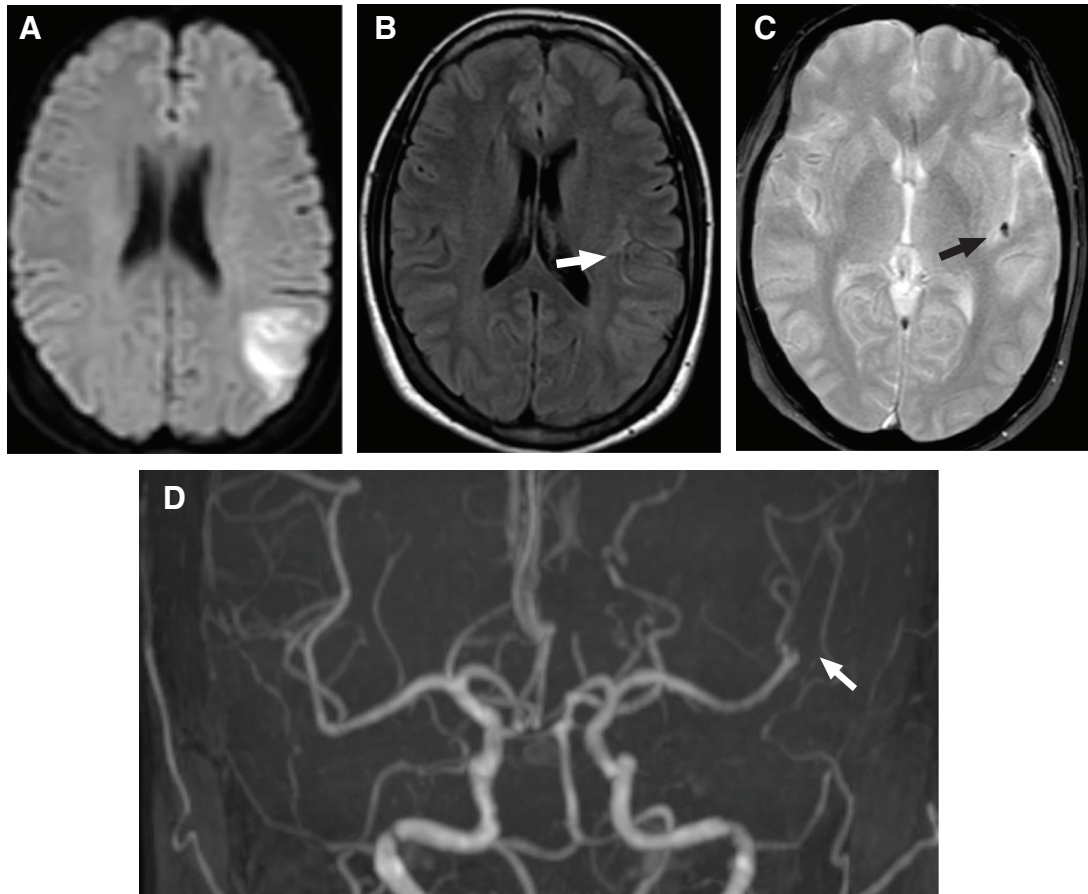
(A) Diffusion-weighted imaging revealed a high intensity area of the left parietal lobe. (B) Hyperintensity vessel sign was positive on FLAIR (white arrow). (C) Susceptibility vessel sign was positive on T2*-weighted imaging (black arrow). (D) MRA revealed left MCA M2 segment occlusion (white arrow). MCA: middle cerebral artery
